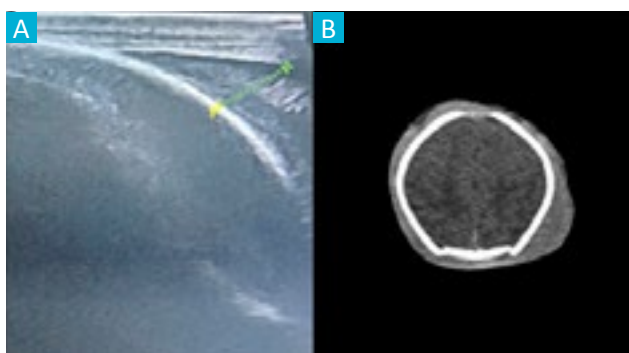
Ultrasound demonstrating the left side of the subgaleal hemorrhage, with 11.10 mm (A). Cranial tomography performed at 24 hours of life, showing an extensive hemorrhage (B).
